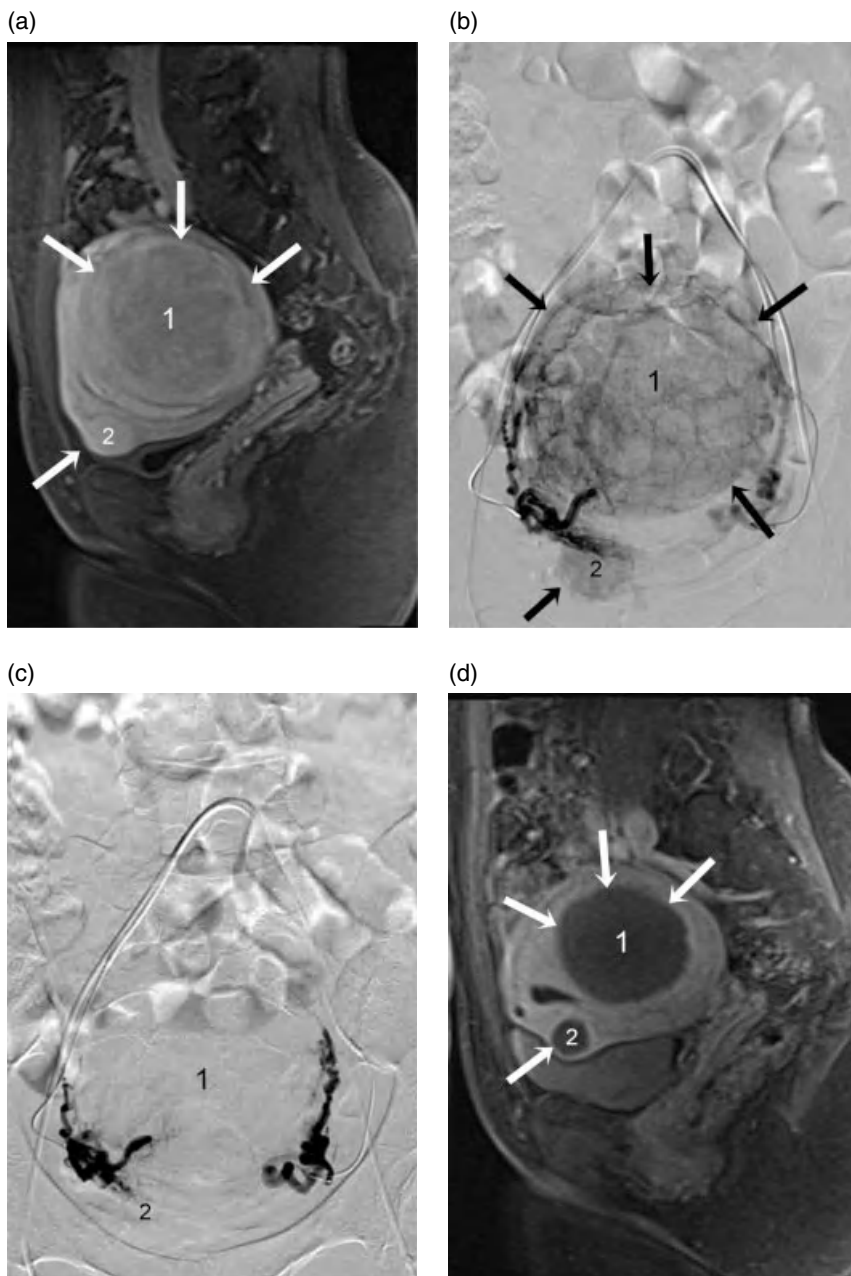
The patient is a 42-year-old woman with heavy menstrual bleeding and dysmenorrhea secondary to fibroids. (a) Sagittal view, T1-weighted contrast-enhanced MRI image showing one large fibroid (*arrows indicating margins of fibroid marked 1*) and one small fibroid anteriorly (*arrow indicating fibroid marked 2*). Both fibroids enhance with contrast as the fibroids are white, similar in intensity to the surrounding myometrium. (b) Initial angiographic frontal view image before embolization with bilateral simultaneous uterine artery injection, with arrows indicating the vessels and parenchymal blush of the fibroids. (c) Angiographic image of uterine arteries after embolization showing the main uterine arteries remaining patent but the fibroid branches occluded and the fibroid parenchymal blush gone. (d) Sagittal view, T1-weighted contrast-enhanced MRI image 3 months after uterine embolization. The fibroid residual tissue is now dark, the myometrium is normally enhancing and the fibroid tissue is significantly diminished in diameter. The patient's symptoms had completely resolved at the time of this follow-up visit.
